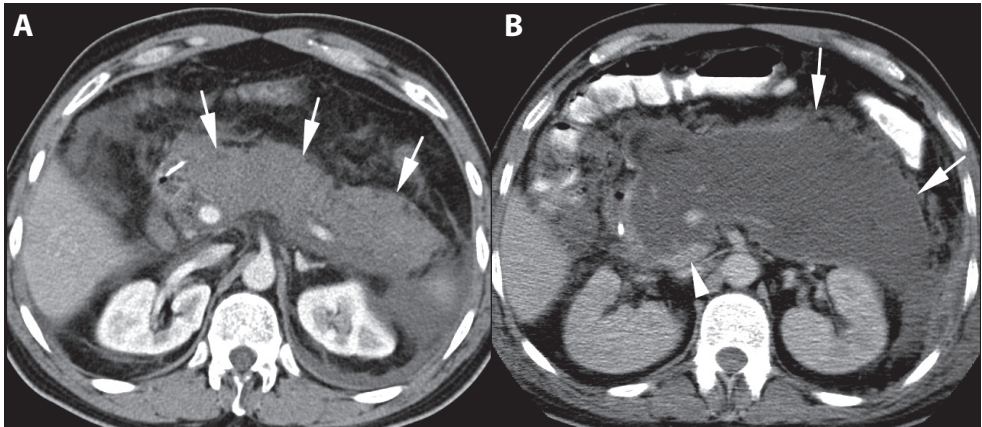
Subtotal necrosis – pattern 4. (A) CT on the day of admission shows a large area of hypo-perfusion of the pancreatic body and tail and part of the head, likely representing >90% necrosis (arrows). (B) Follow-up CT on day 14 confirms necrosis of the pancreatic parenchyma for more than 90% with small area of remaining vital pancreatic parenchyma in the pancreatic head (arrowhead). There is an associated heterogeneous partially encapsulated acute necrotic collection (arrows).
